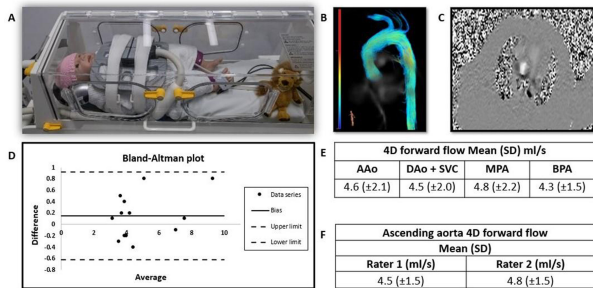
A) MRI-compatible incubator with specialised small coils inside; B) 4D Flow MRI anatomical aortic arch 3D reconstruction; C) 2D Flow MRI ascending aorta at the level of the pulmonary arteries; D) Bland-Altman plot, bias 0.15, 95% limits of agreement -0.62 to 0.92; E) 4D forward flow measurements; AAo, ascending aorta; DAo, descending aorta; SVC, superior vena cava; MPA, main pulmonary artery; BPA, branch pulmonary arteries; F) Ascending aorta 4D flow between two raters.
